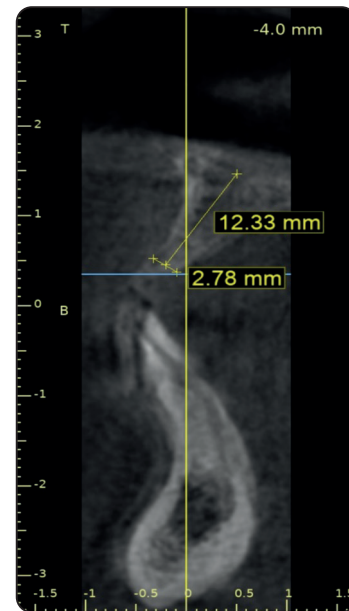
showing pre-operative CBCT
